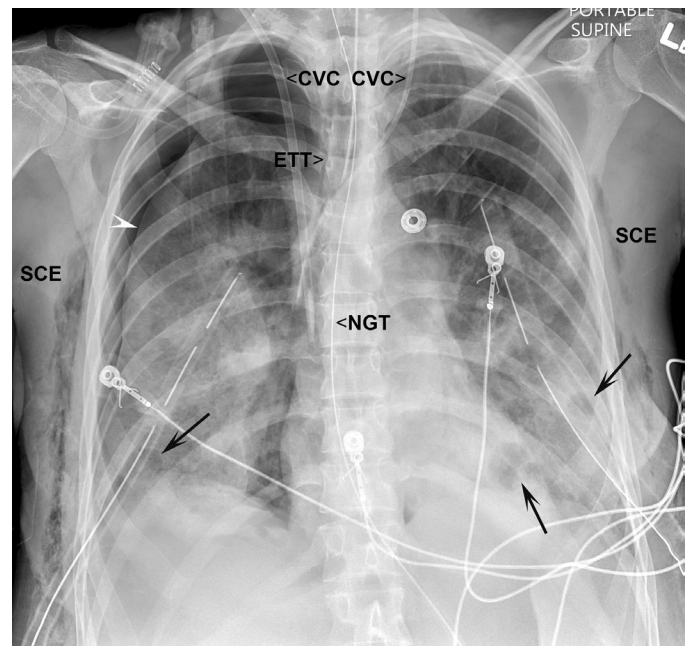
■ Anteroposterior (AP) supine chest x-ray. Bilateral focal lucencies (*black arrows*) within areas of airspace opacity suggest septic emboli or parenchymal necrosis. There is an associated right pneumothorax (white arrowhead delineates lung edge). ETT, bilateral internal jugular CVCs (central venous catheters), bilateral chest tubes, and NGT (nasogastric tube) are in proper position. Subcutaneous emphysema (SCE) is secondary to recent chest tube insertion.
